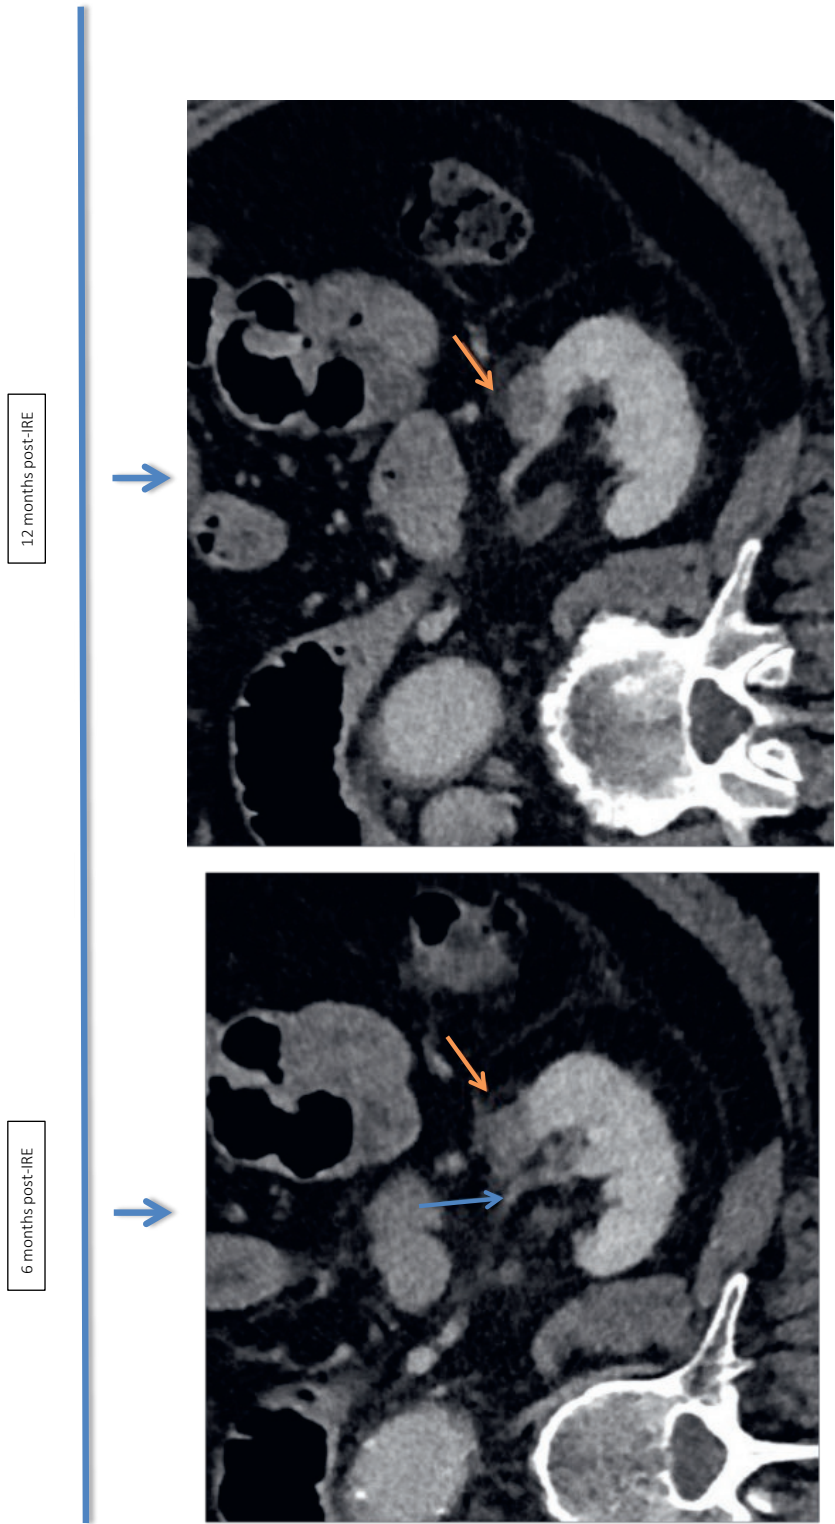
Evolution through time of CT ablation zone. From left to right: Tumour pre-IRE (4.5 cm³); Perioperative ablation zone immediately after ablation (14.8 cm³); 3 months post-IRE ablation zone (4.4 cm³); 6 months post-IRE ablation zone (3.9 cm³); 12 months post-IRE ablation zone (2.5 cm³). Notice the proximity of the tumour pre-IRE (green arrow) and the ablation zone post-IRE (orange arrow) to the ureter (yellow arrow) and the renal vasculature in the hilum (blue arrow).
